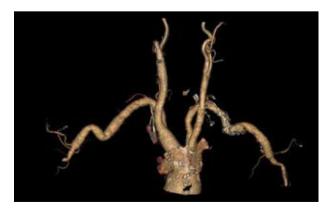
Favourable left carotid artery anatomy in multi-sliced angio-computed tomography
